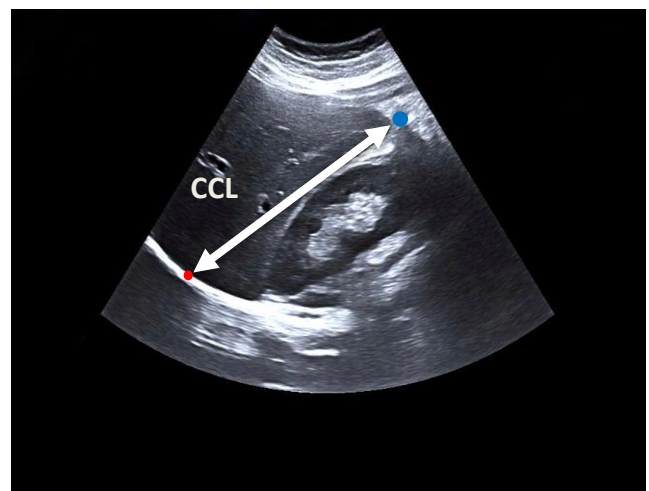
Digital ultrasonography of liver showing measurement of CCL of liver.
